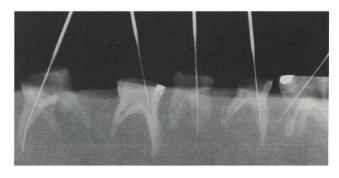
Radiograph of tooth length as measured by Root ZX.
